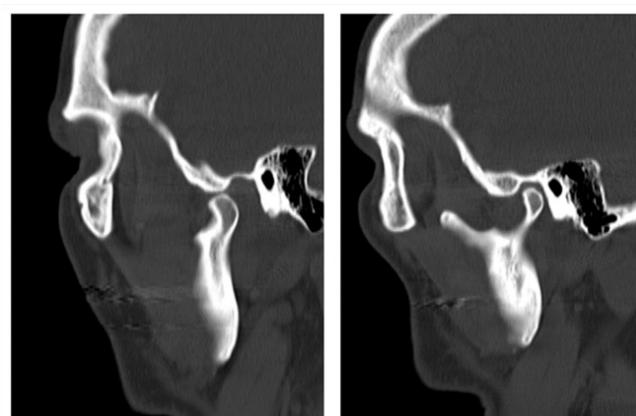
CT image showing a displaced right temporomandibular joint compared to the intact left TMJ.
